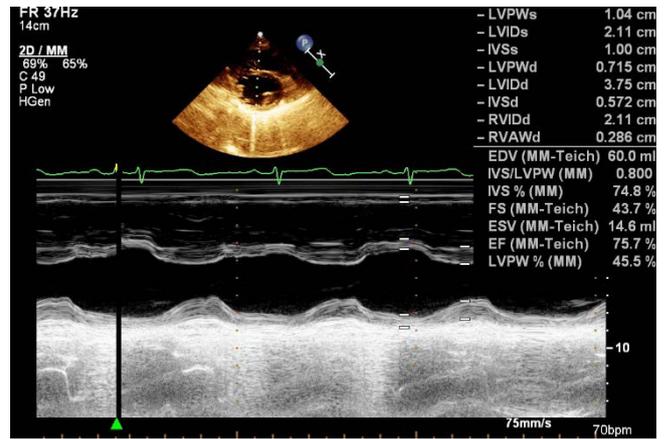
Parasternal short axis view at the level of the papillary muscles of the left ventricle showing the left ventricular ejection fraction of 75%.
